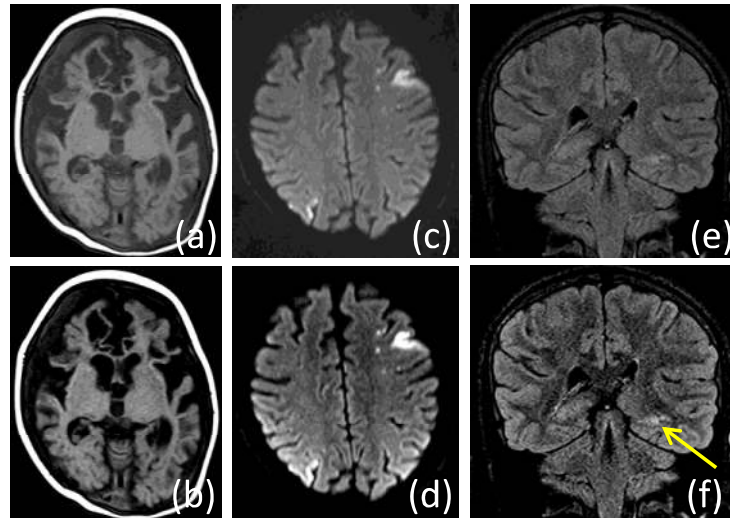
(a) Input T1 weighted MRI (Test 1), (b) optimized enhanced image corresponding to Test 1 (DSR parameters $a=0.0608$, $b=5.47 \times 10^{-9}$, $n_q=23$, $n_n=15$, $\lambda=2.11$). (c) Input DWI (Test 2), (d) optimized enhanced image corresponding to Test 2 (DSR parameters: $a=0.0466$, $b=5.62 \times 10^{-9}$, $n_q=24$, $n_n=20$, $\lambda=2.15$). (e) Input FLAIR (Test 3) images, (f) optimized enhanced image corresponding to Test 3 (DSR parameters: $a=0.1987$, $b=6.343 \times 10^{-9}$, $n_q=24$, $n_n=24$, $\lambda=2$).
